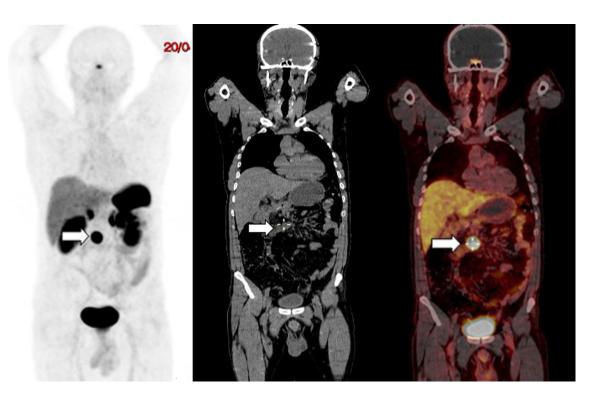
59-year-old patient with a duodenal NET. The ⁶⁸Ga-DOTANOC PET/CT showed a 20 x 22 x 18 lymph node with somatostatin receptor overexpression located in the mesentery (arrows), above the third part of the duodenum with a SUVmax of 57.6 (Krenning 4/4). A. Maximal intensity image. B. Low-dose CT coronal view. C. PET/CT fusion image.
